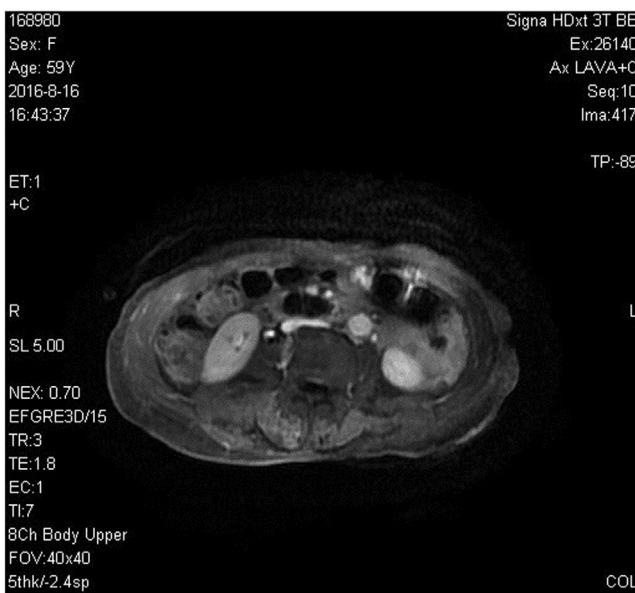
MRI scan showing a mass with solid and cystic components in the head of the pancreas.
